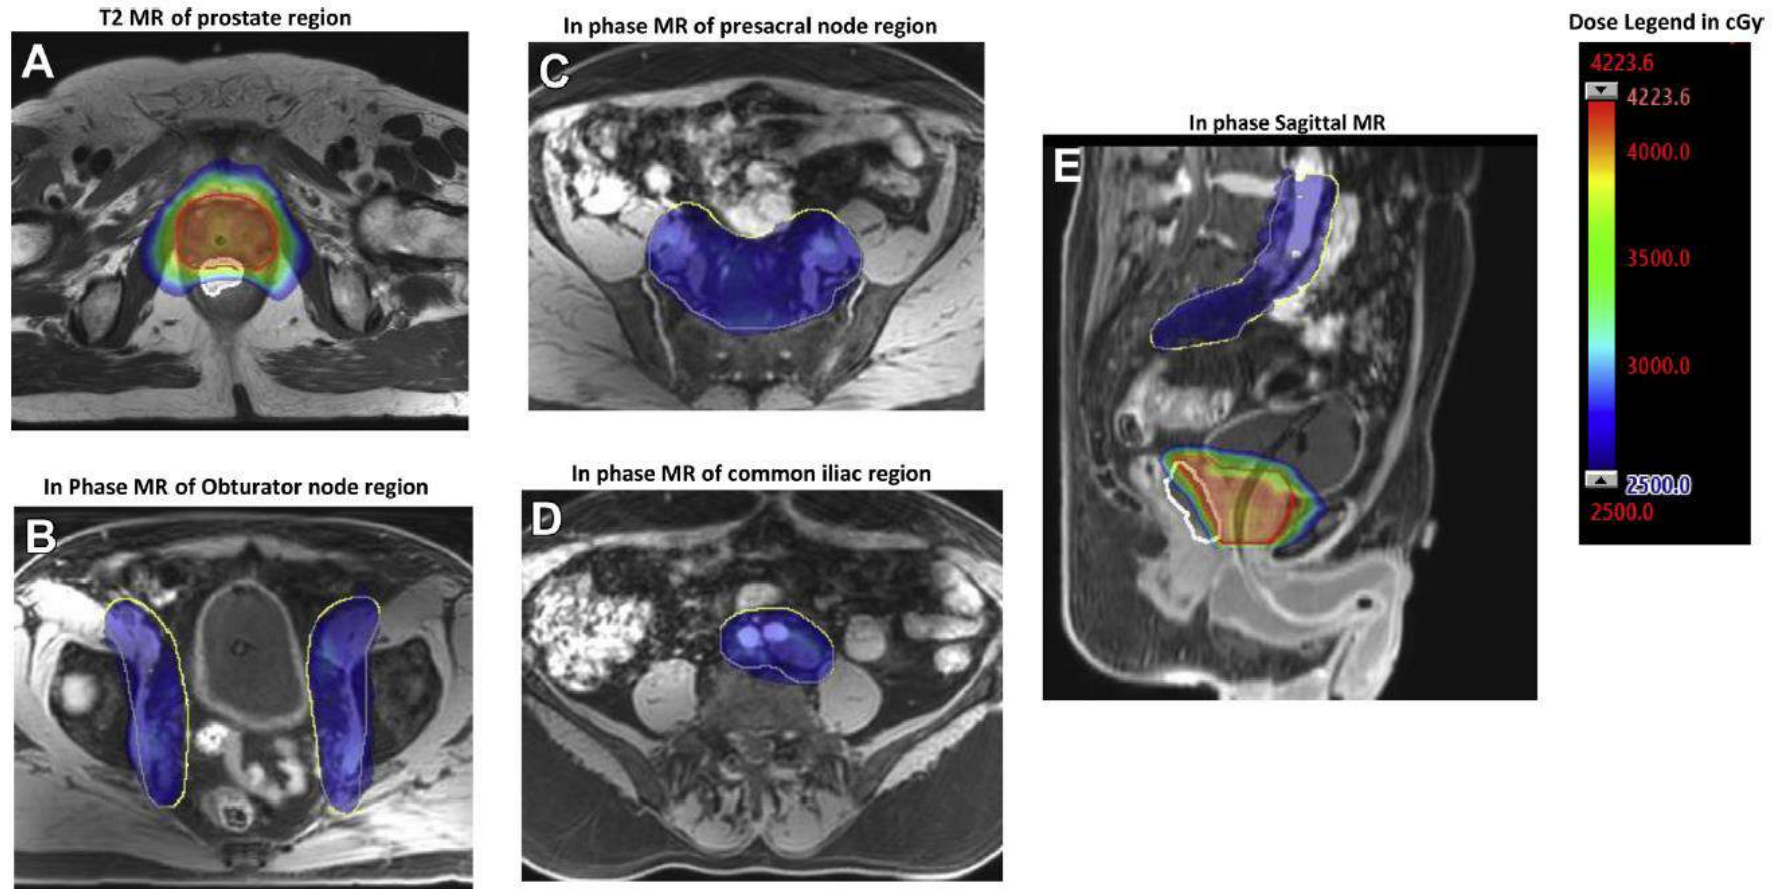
Example of volumetric arc dose distribution of prostate concomitant with pelvic node radiation overlay on (A) axial T2-weighted, (B-D) axial mDIXON, and (E) sagittal mDIXON water contrast magnetic resonance image. Images are in transverse level of (A) prostate, (B) obturator region, (C) presacral region, and (D) common iliac region. Planning target volume of the prostate plus seminal vesicles, pelvic nodes and rectal spacer are contoured red, yellow, and white, respectively. Highlighted red/pink and blue areas correspond to 40 Gy and 25 Gy, respectively.
